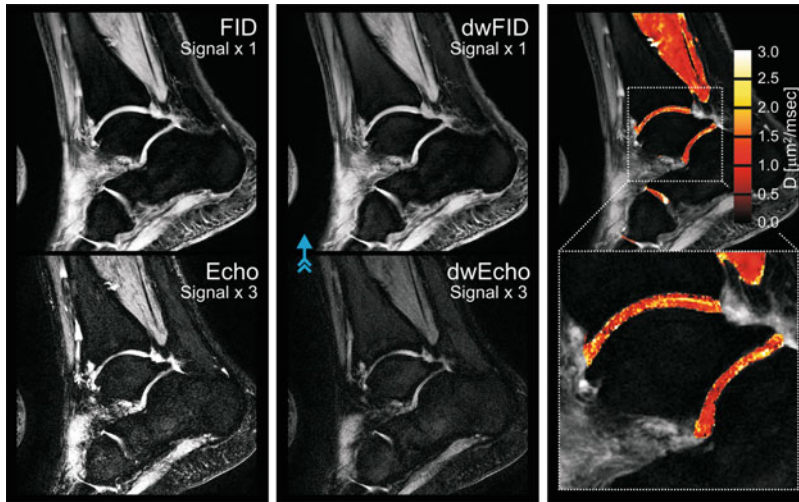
High-resolution quantitative 3D DESS DWI of normal appearing cartilage in the ankle joint at 3.0 T. (Left) Sagittal nondiffusion-weighted DESS scan. (Middle) DESS scan with diffusion-sensitizing crusher moments along the direction indicated by the blue arrow. (Right) Fusion of the derived diffusion map
